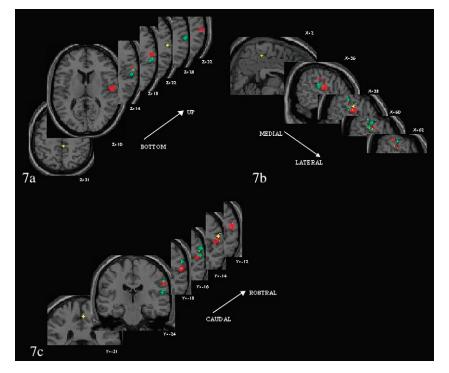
Somatotopic distribution of SI responses obtained by pooling the 45 stimulations of SI. Stimulation sites were plotted using their x, y and z stereotactic coordinates on a standardized MRI. Each stimulation site is symbolized by a cross: red, face; green, hand; yellow, lower limb. Horizontal (a), sagittal (b) and coronal (c) reconstructed MRI slices are represented.
